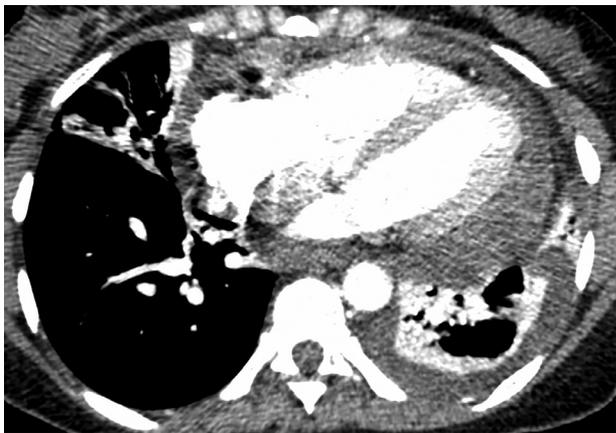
A 26-year-old female with SLE and chest pain. CT pulmonary angiogram shows pericardial and left pleural effusions. SLE, systemic lupus erythematosus.
